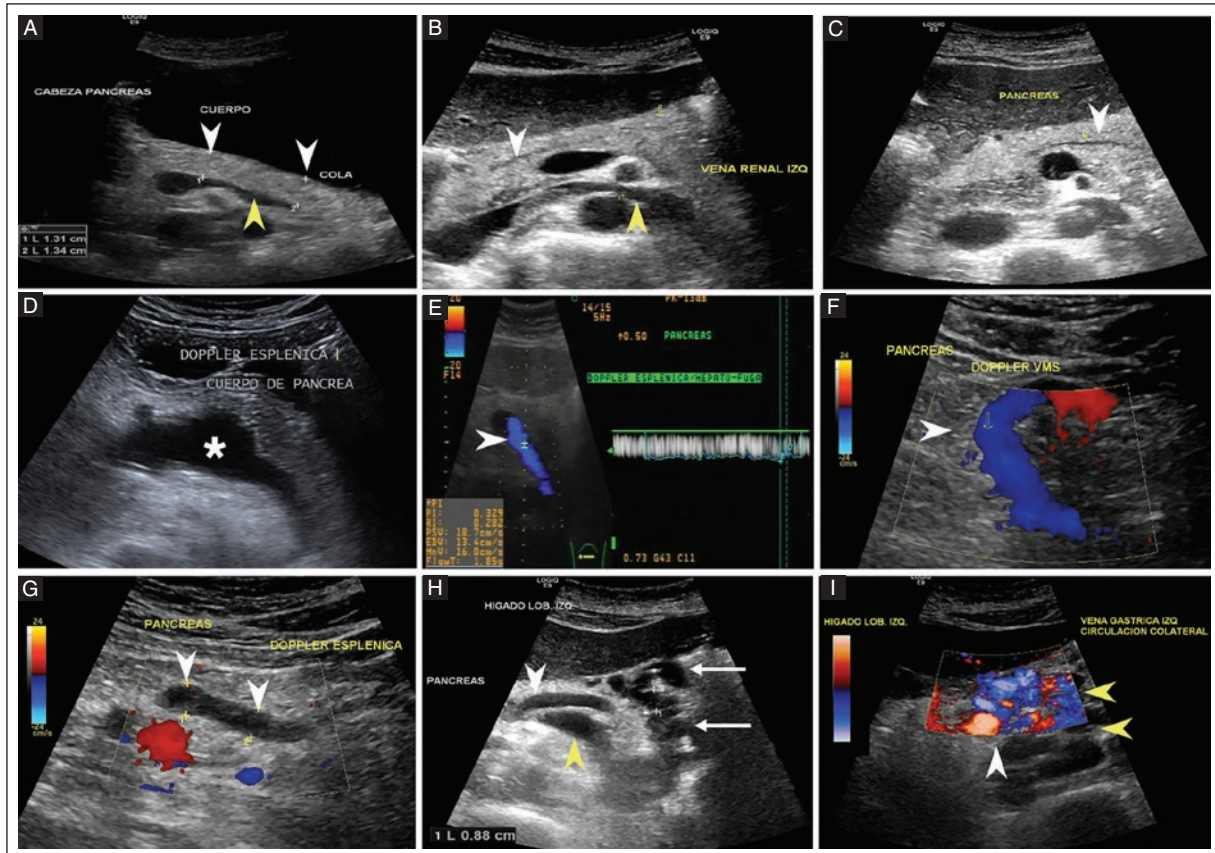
Morphologic US duplex findings of the pancreatic region in portal hypertension assessment. A: a 32-year-old woman, transverse grayscale view showing all segments of the pancreas (white arrowheads) and splenic vein (yellow arrowhead) with normal features with AP measurement of the pancreatic body and tail of 13 mm. B: a 39-year-old woman, grayscale US transverse view showing normal pancreas and Wirsung duct 2.6 mm (not shown) (white arrowhead) and left renal vein (yellow arrowhead) until it reaches the vena cava. C: a 48-year-old man with CLD. Grayscale US transverse view showing normal pancreas and Wirsung duct (white arrowhead). D: a 46-year-old woman with CLD. Grayscale US transverse view of the pancreas showing aneurysmal dilatation (22 mm, not shown) of the splenic vein (white asterisk). Hemodynamic US duplex findings of the pancreatic region in portal hypertension assessment. E: a 41-year-old male with portal hypertension; US duplex transverse view of the pancreas showing hepatofugal flow in the splenic vein at a velocity of 18.7 cm/s (arrowhead). F: a 48-year-old man with idiopathic portal hypertension. F: color Doppler sagittal view of the superior mesenteric vein (white arrowhead) with patency and hepatofugal flow. G: color Doppler US, transverse view of the pancreas with endoluminal hypoechoic material along the entire length of the splenic vein (white arrowheads) with absent flow due to chronic thrombosis. H: a 59-year-old woman with CLD. Grayscale US transverse view of the pancreas showing normal artery (white arrowhead) and splenic vein (yellow arrowhead) and 8.8 mm peripancreatic collateral circulation (white arrows). I: a 59-year-old woman with CLD, color Doppler US transverse view showing the left gastric vein (white arrowhead) and the adjacent collateral circulation (yellow arrowheads).
